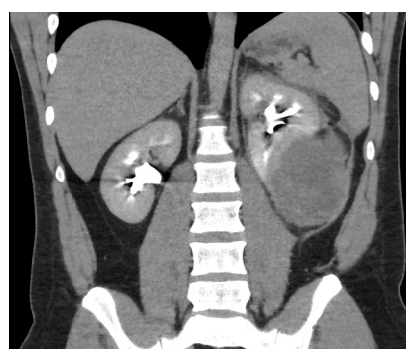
Coronal view of a delayed phase CT showing a large perirenal haematoma without obvious evidence of urinoma.
